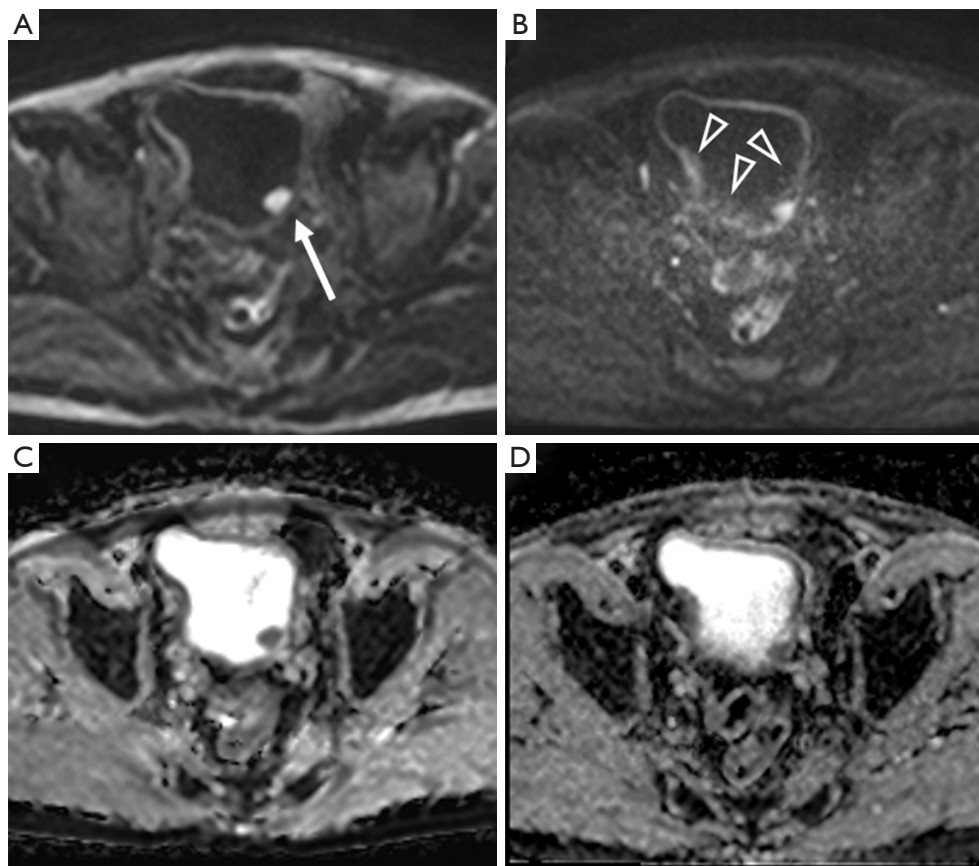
Comparison between iShim and SS-EPI DWI in patients with non-muscle-invasive high-grade urothelial carcinoma. The scores of anatomic details, distortion, lesion conspicuity, artifacts, and overall image quality are described below. (A) iShim DWI showing a bladder cancer not involving the muscular layer (white arrow); the scores are 4, 5, 5, 5, and 5 points, respectively. (B) SS-EPI DWI showing the lesion invading the muscular layer with many artifacts (triangles) around the bladder wall; the scores are 3, 4, 4, 3, and 3 points, respectively. (C) iShim ADC showing a relatively homogeneous urine signal. (D) SS-EPI ADC showing an uneven urine signal. iShim, integrated slice-specific dynamic shimming; SS-EPI, single-shot echo-planar imaging; DWI, diffusion-weighted imaging; ADC, apparent diffusion coefficient.
